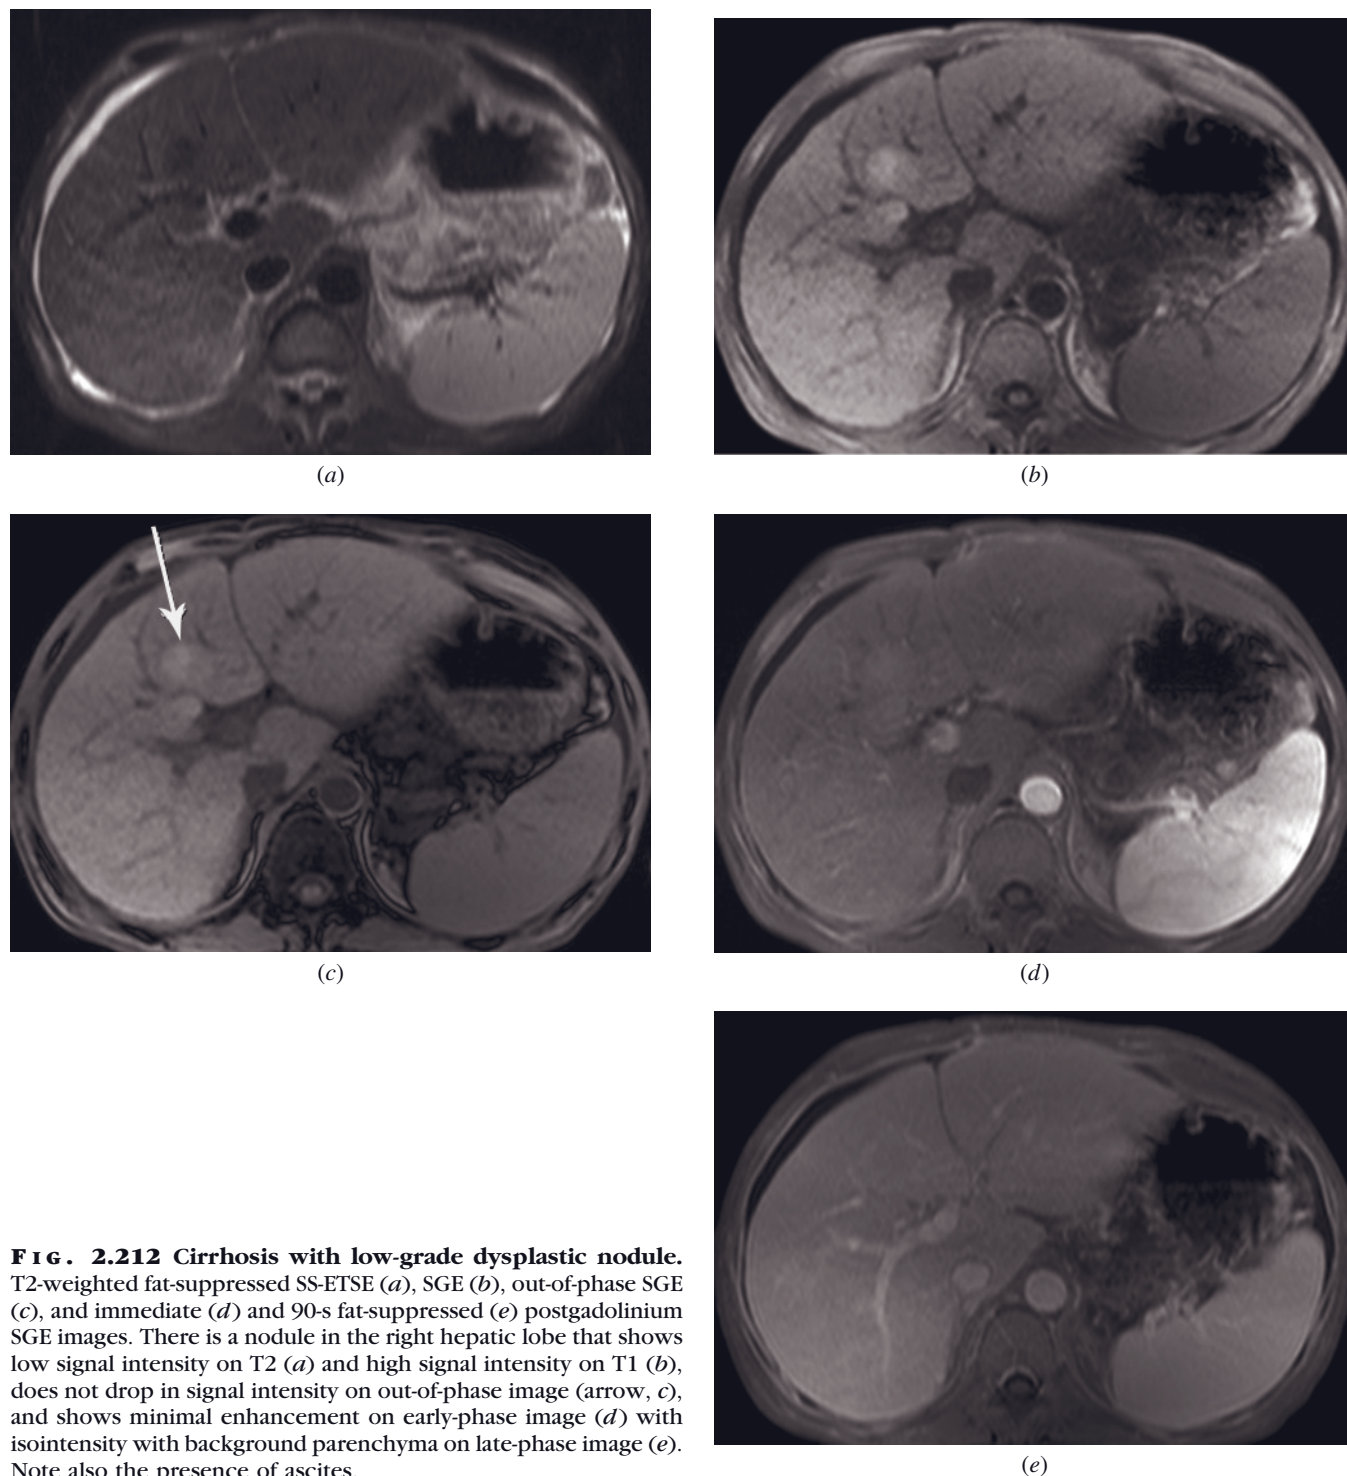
Cirrhosis with low-grade dysplastic nodule. T2-weighted fat-suppressed SS-ETSE (*a*), SGE (*b*), out-of-phase SGE (*c*), and immediate (*d*) and 90-s fat-suppressed (*e*) postgadolinium SGE images. There is a nodule in the right hepatic lobe that shows low signal intensity on T2 (*a*) and high signal intensity on T1 (*b*), does not drop in signal intensity on out-of-phase image (arrow, *c*), and shows minimal enhancement on early-phase image (*d*) with isointensity with background parenchyma on late-phase image (*e*). Note also the presence of ascites.
